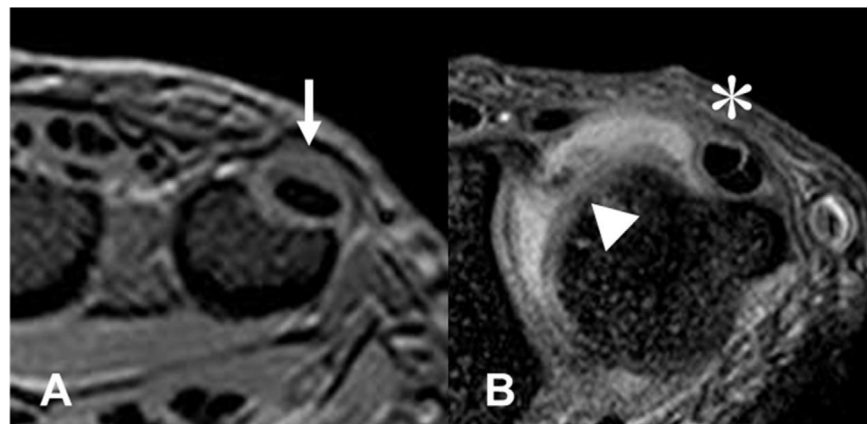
Magnetic resonance images showing abnormal findings of the ECU tendon and DRUJ. a Fluid collection around the ECU tendon was considered to be present when a peritendinous high-intensity area was observed on axial T2-weighted images (white arrow). b Fluid collection in the DRUJ was considered to be present when an intra-articular high-intensity area was observed on axial T2-weighted images (white arrowhead). Longitudinal splitting of the ECU tendon was observed as a splitting high-intensity area within the ECU tendon on axial T2-weighted images (asterisk). ECU: extensor carpi ulnaris; DRUJ: distal radioulnar joint.
